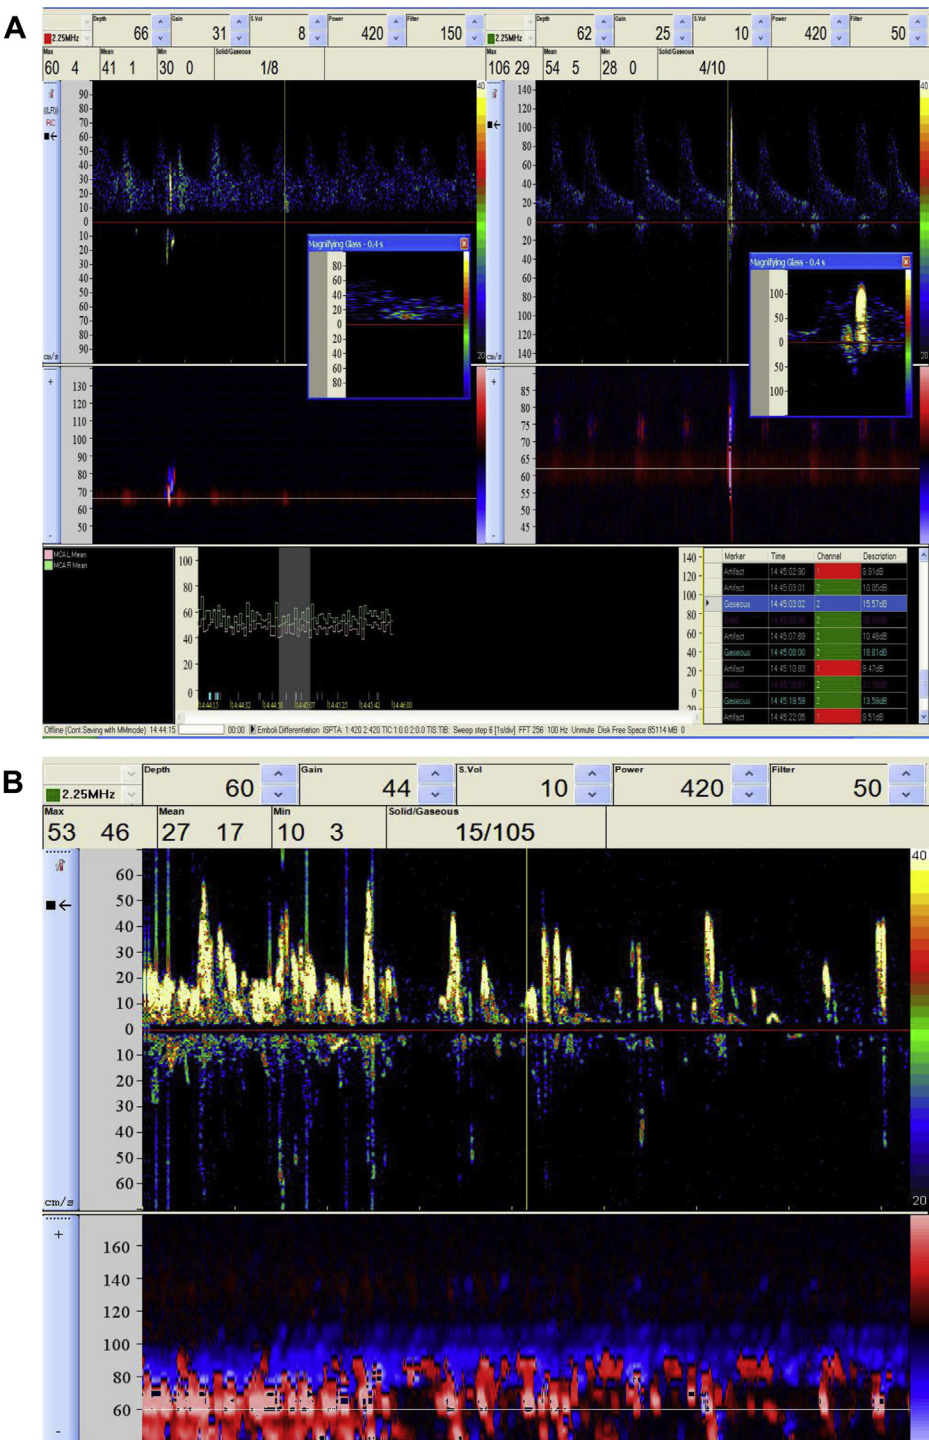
A, Transcranial Doppler (Embodop DWL): *left*, solid embolus; *right*, gas embolus. B, Embolic cluster of high-intensity transient signals (HITSs).
